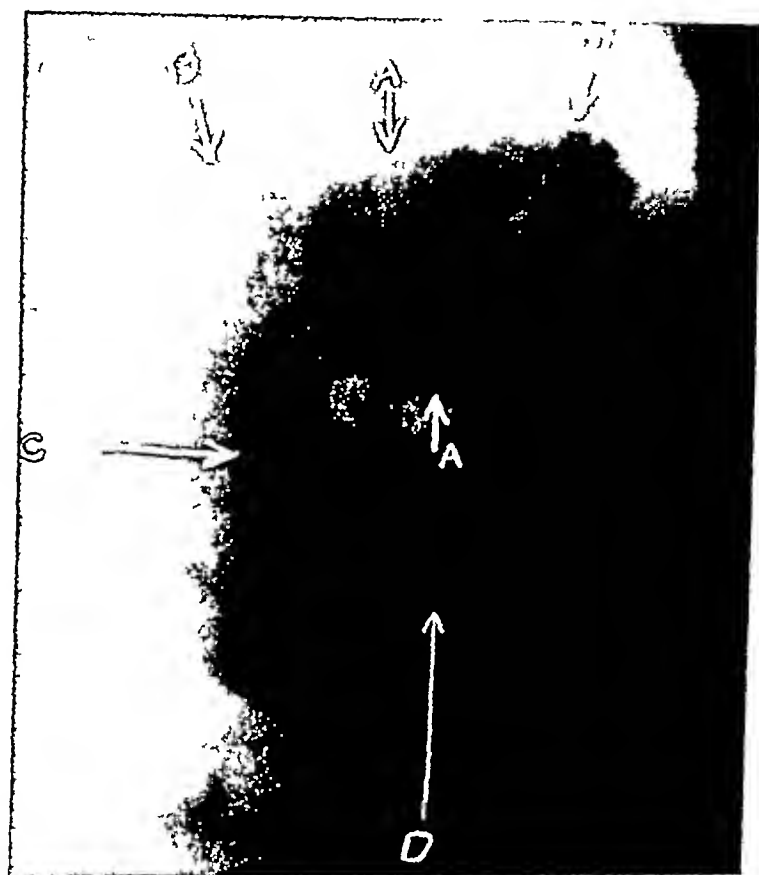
Roentgenogram demonstrating the typical picture of the redundant duodenum. The two fixed points in the superior duodenum, the two angulations, the extra loop, and the stasis are clearly shown.
